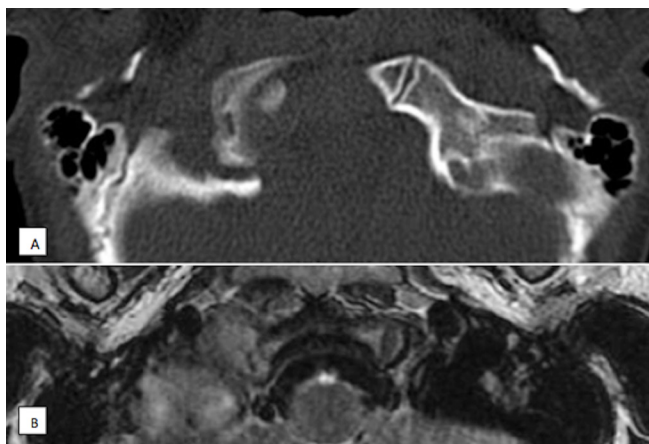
CT axial osseous window (A) and axial T2-weighted image on MRI, showing relationship with the hypoglossal canal.
